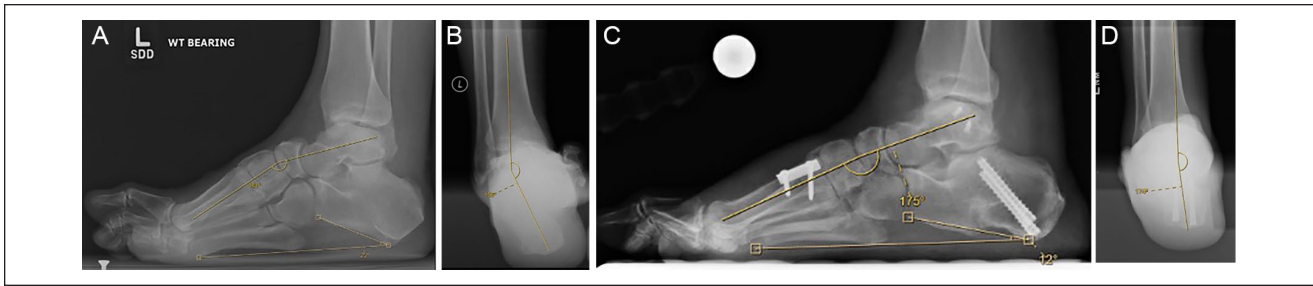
(A) Preoperative Meary angle and calcaneal pitch of 19 and 25 degrees, respectively, in a 59-year-old male on a lateral radiograph. (B) Preoperative hindfoot alignment of 24 degrees of varus on a hindfoot alignment view. (C) Postoperative Meary angle and calcaneal pitch of 5 and 12 degrees, respectively. (D) Postoperative hindfoot alignment of 6 degrees of varus.
